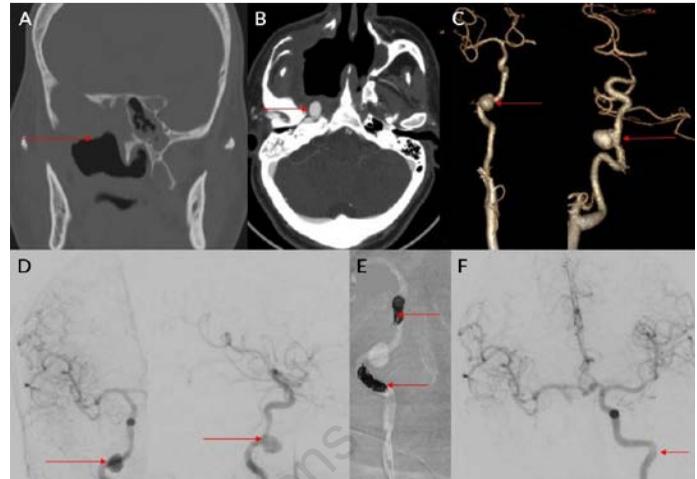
Internal carotid artery (ICA) pseudoaneurysm. (A) Computed tomography (CT) face bone window coronal image shows bony destruction involving the maxillary sinus with postoperative changes as a part of debridement for mucormycosis. (B) Contrast-enhanced CT (CECT) face axial image shows a pseudoaneurysm arising from the right internal carotid artery lacerum part. (C) Volume-rendered images from the CECT face show the pseudoaneurysm facing medial and anterior. (D) Anteroposterior and lateral images from the right ICA angiogram show the pseudoaneurysm arising from the right ICA lacerum segment. (E) Coiling of the artery was done distal and proximal to the pseudoaneurysm. (F) Post embolization angiogram from the left ICA shows filling of bilateral middle cerebral and anterior cerebral arteries with no perfusion defects.
